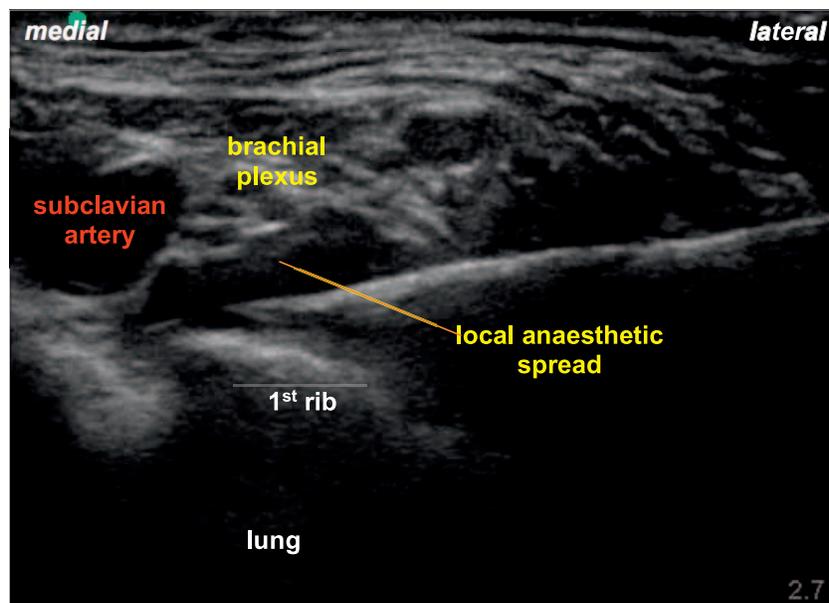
Ultrasound image demonstrating needle tip in “corner pocket.” Note the brachial plexus has been lifted up by the injection of local anaesthetic and has become easier to visualise.
